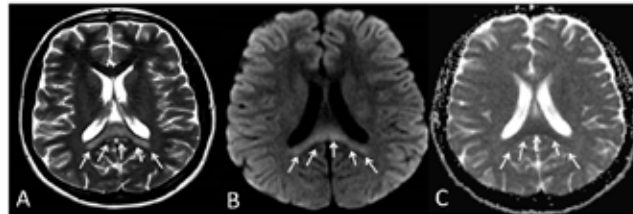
18-year-old female patient. Axial T2-weighted (A) brain MRI shows diffuse hyperintensity increase in the corpus callosum splenium and diffusion restriction in diffusion-weighted imaging (B) and ADC mapping (C).
